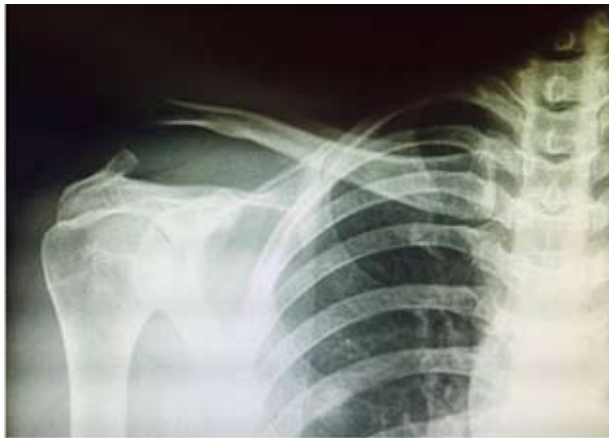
A radiograph showing acromioclavicular joint dislocation (Rockwood type IV).
